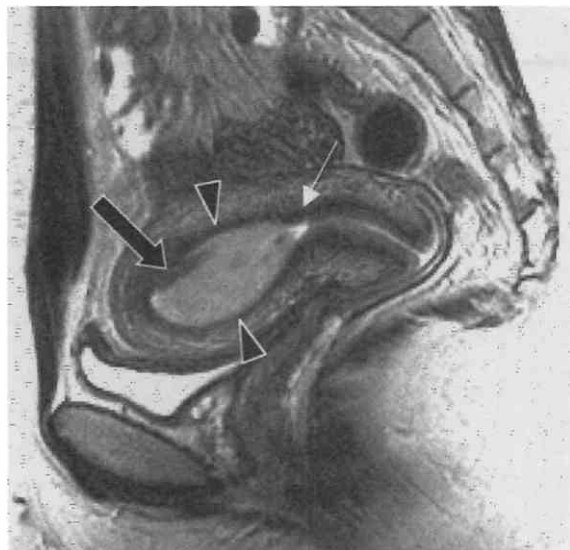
Endometrial polyp in a 31-year-old woman. Sagittal T2-weighted, fast spin-echo image shows the polyp (arrowheads) outlined by a small amount of fluid (thin white arrow). The thin fibrous core of the polyp (black arrow) can be seen. The mass shows no evidence of invasion of the junctional zone.
